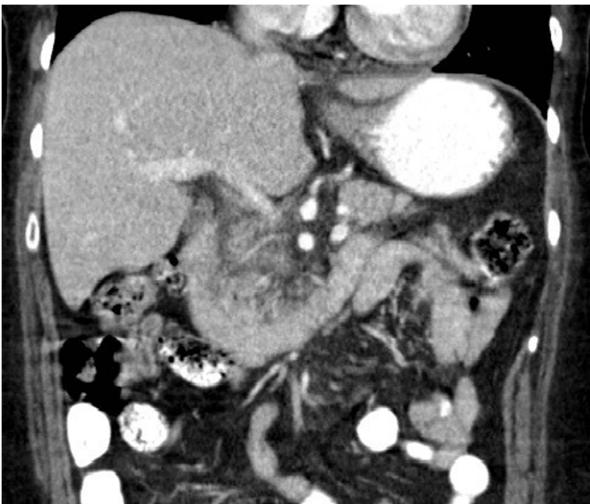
Coronal view of CT scan of abdomen and pelvis with IV and oral contrast showing haziness in the peripancreatic fat plane.
